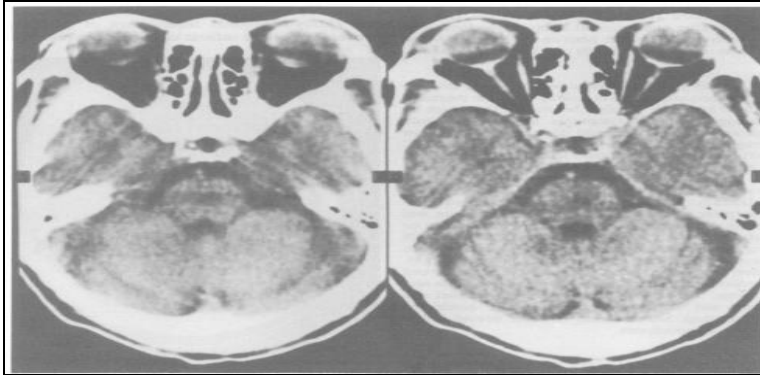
MRI showing an infarct of about 5 mm on dorsal pons along with encephalopathy changes.
